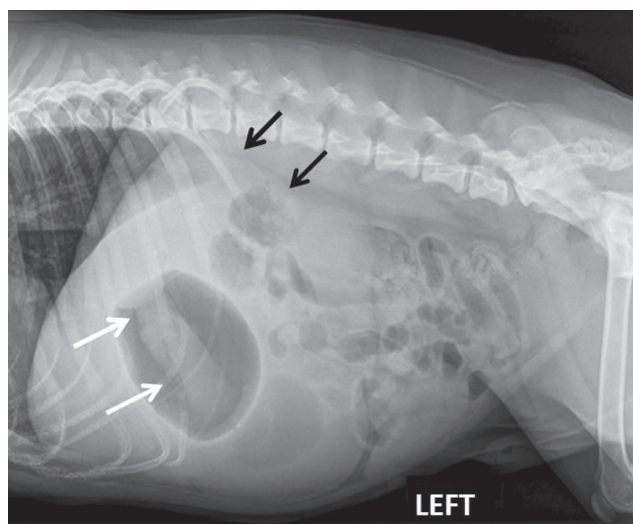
On the left lateral radiographic view (C) gas is positioned in the pylorus providing contrast to allow for identification of linear soft tissue opaque material extending from the pylorus (white arrows) into the duodenum (black arrows).
